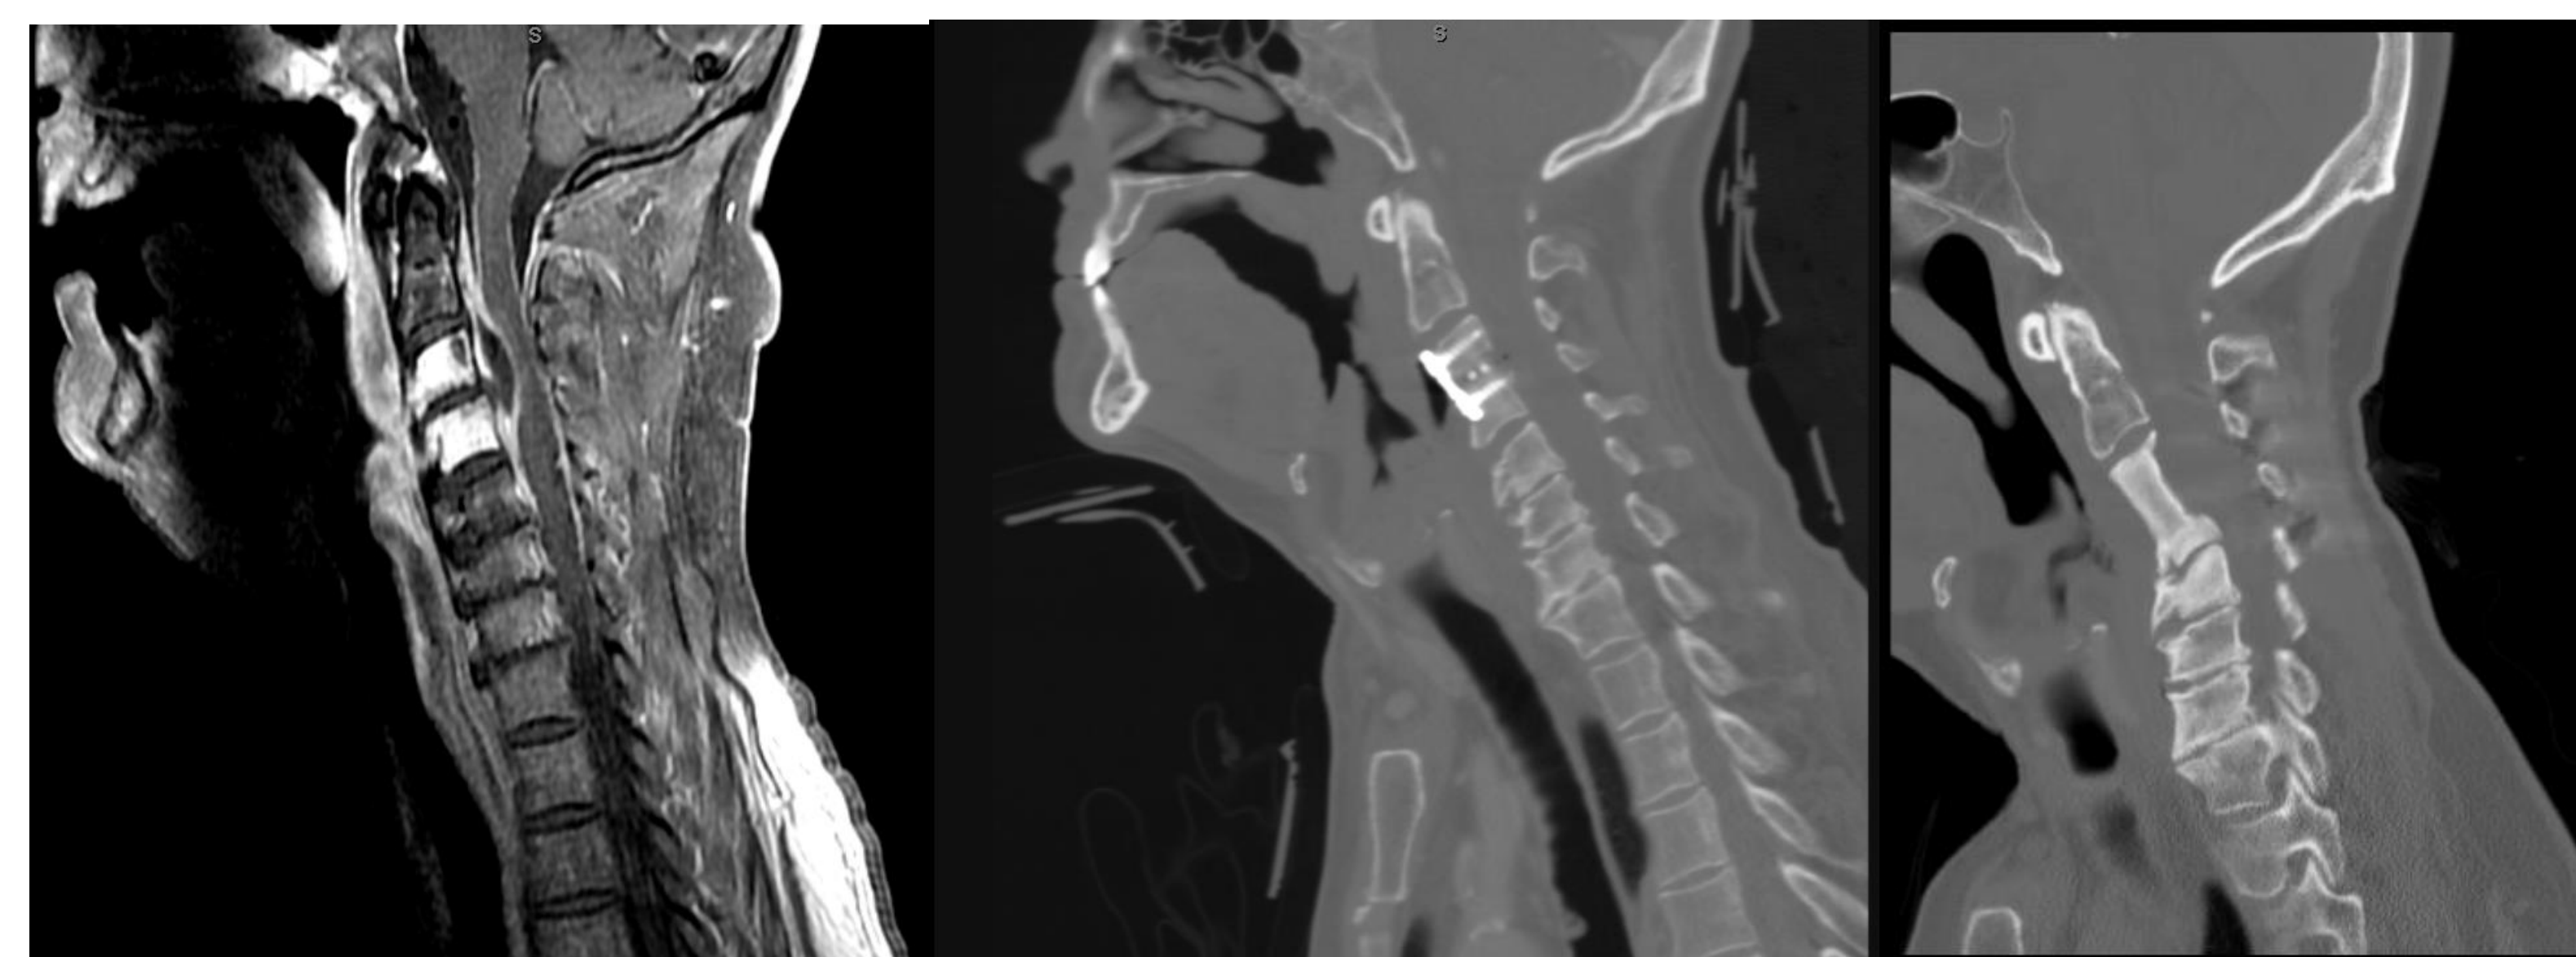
A. MRI Cspine Sagittal View, showing osteomyelitis of C3-C4 with epidural abscess. B. CT Cspine Sagittal View following unsuccessful ACDF with communication noted between spinal hardware and pharynx. C. Iliac Bone Autograft replacing the diseased vertebrae
